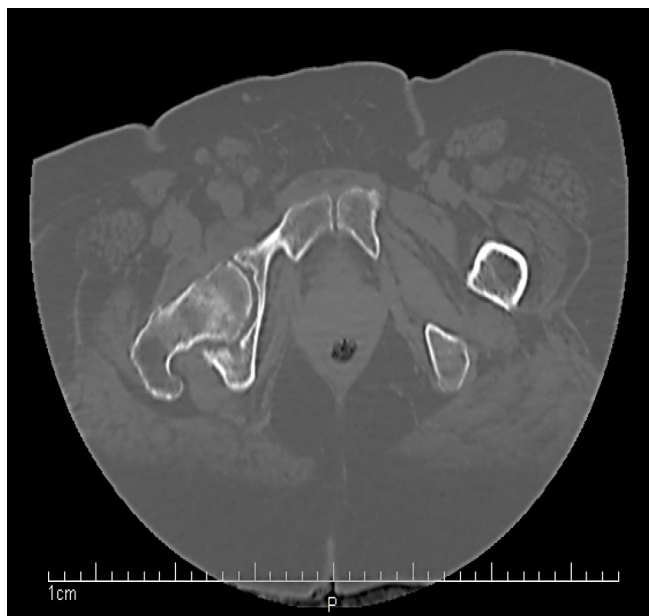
Axial CT scan of the pelvis without contrast: advanced degenerative changes in both hip joints with partial resorption of both femoral heads worse on the left. No fracture was noted
